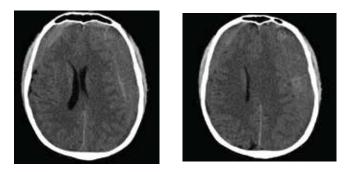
CT brain images showing the patient's bilateral acute on chronic subdural haemorrhage and associated mass effect. The hematoma on the left was greater in depth (2.3cm) than the right (1.5cm), corresponding to the clinical findings of increased tone and decreased power of the right side of the body.
